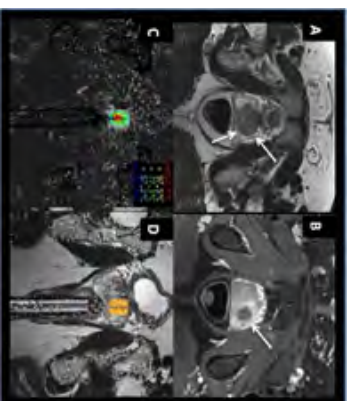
(A) Pre-ablation T2-weighted MRI scan showing a 1.5 cm lesion at the edge of the prostate gland. (B) Intra-ablative T2-weighted MRI scan showing the needle guide positioned at the lesion. (C) Intra-ablative T2-weighted MRI scan showing the laser fiber tip at the lesion. (D) Post-ablation T2-weighted MRI scan showing the ablation zone and the surrounding prostate gland.
